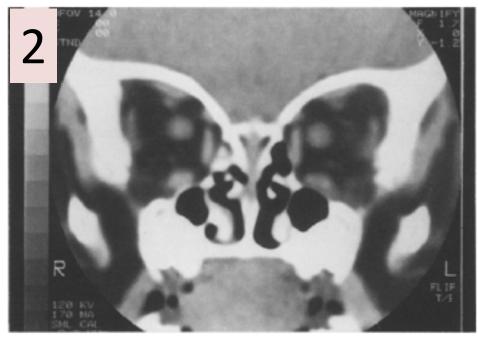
CT scan in 6-month-old infant without strabismus; rectus muscles appear obliquely positioned, but have a normal relationship for the patient's age
